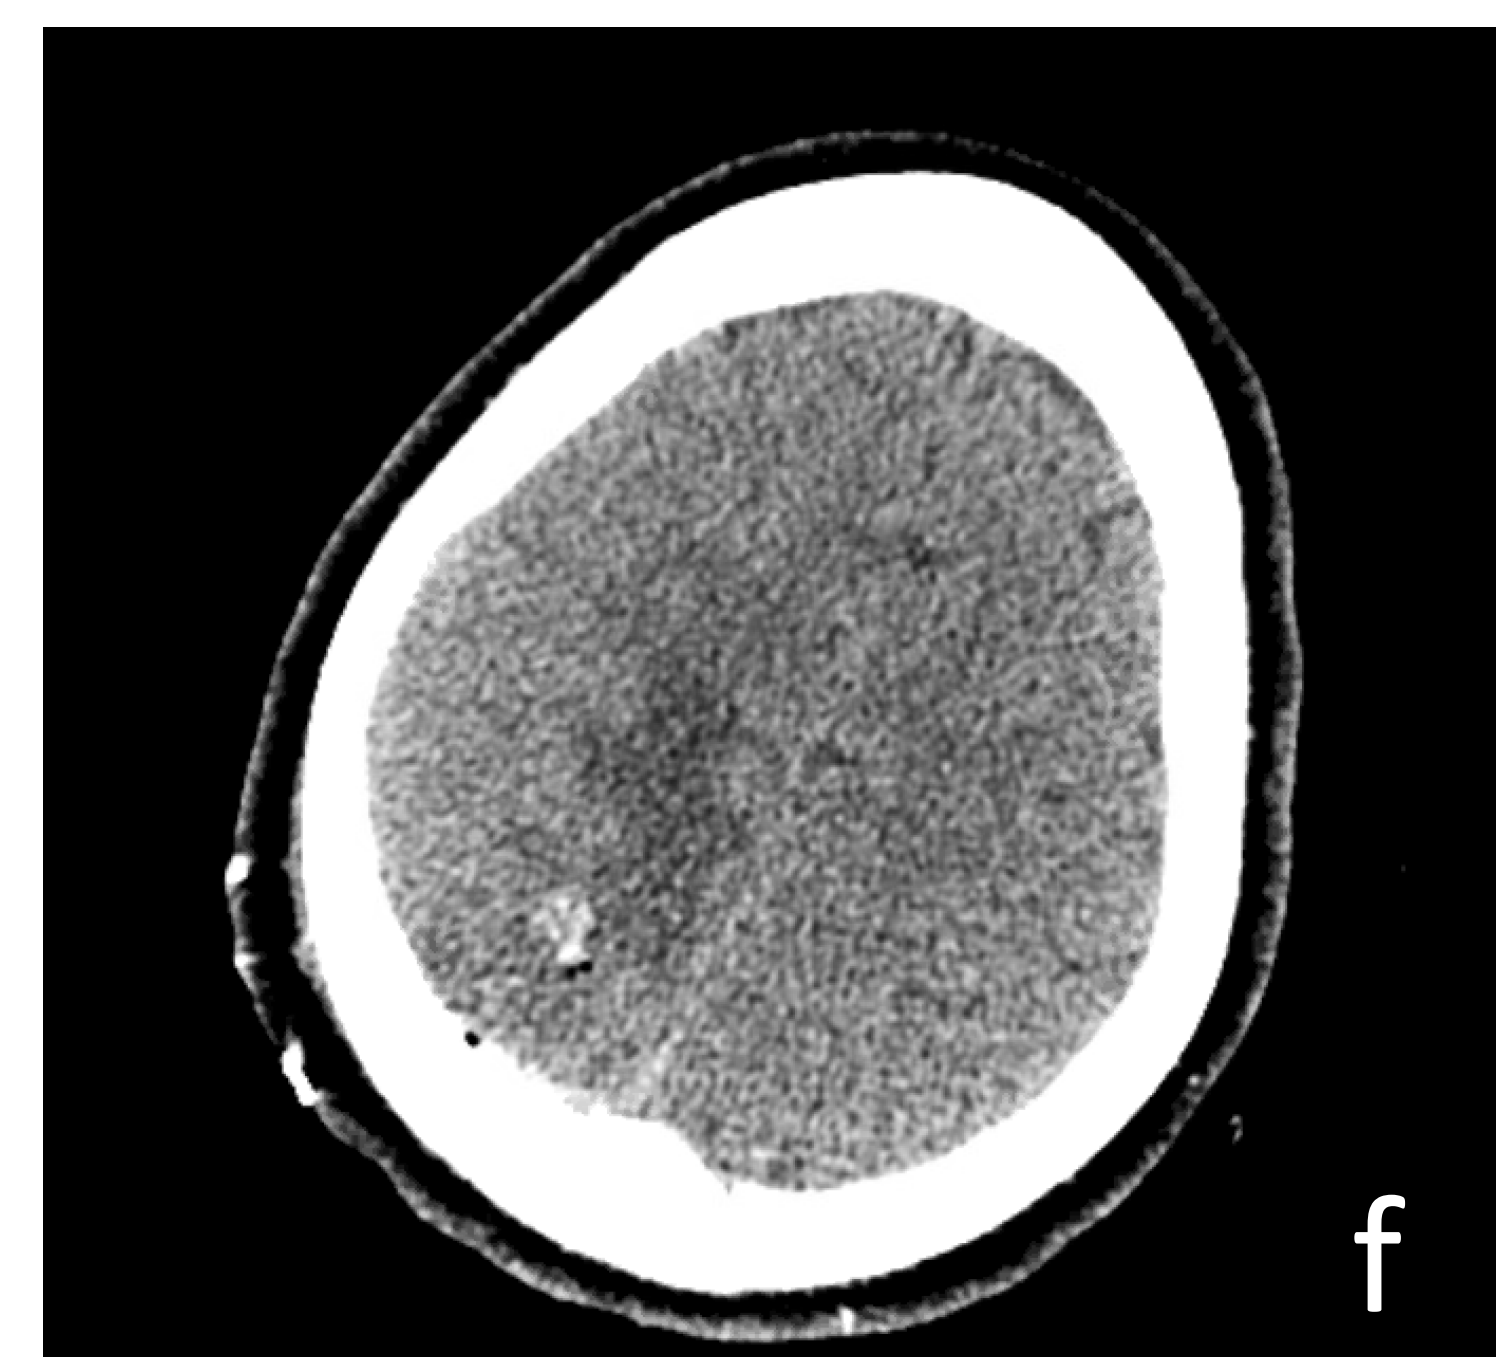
Image f: Brain CT imaging post biopsy showing post operative changes
